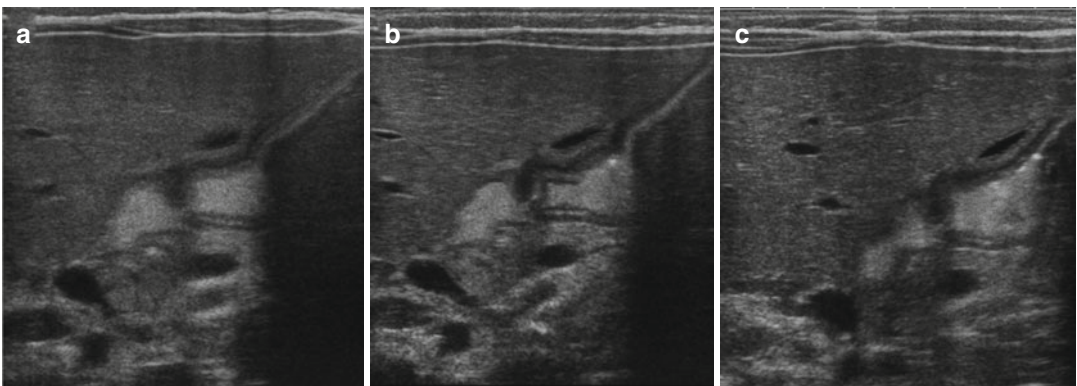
(a–c) Dynamic ultrasound longitudinal scans in newborn show the normal aspect of pylorus muscle, between the stomach and the duodenal cap
